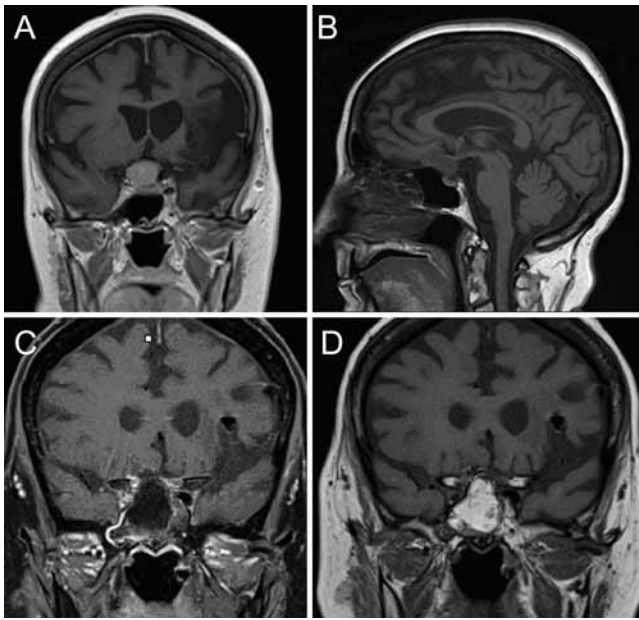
Case 18. Preoperative coronal T1-weighted MR image with Gd enhancement (A) and sagittal T1-weighted MR image without contrast enhancement (B) showing a homogeneously enhancing TSM. The mass is centered at the tuberculum sellae and is right of midline. There is mass effect on the optic nerves and optic chiasm. Postoperative coronal T1-weighted MR images with (C) and without (D) contrast enhancement showing the GTR and hyperintense fat graft.
